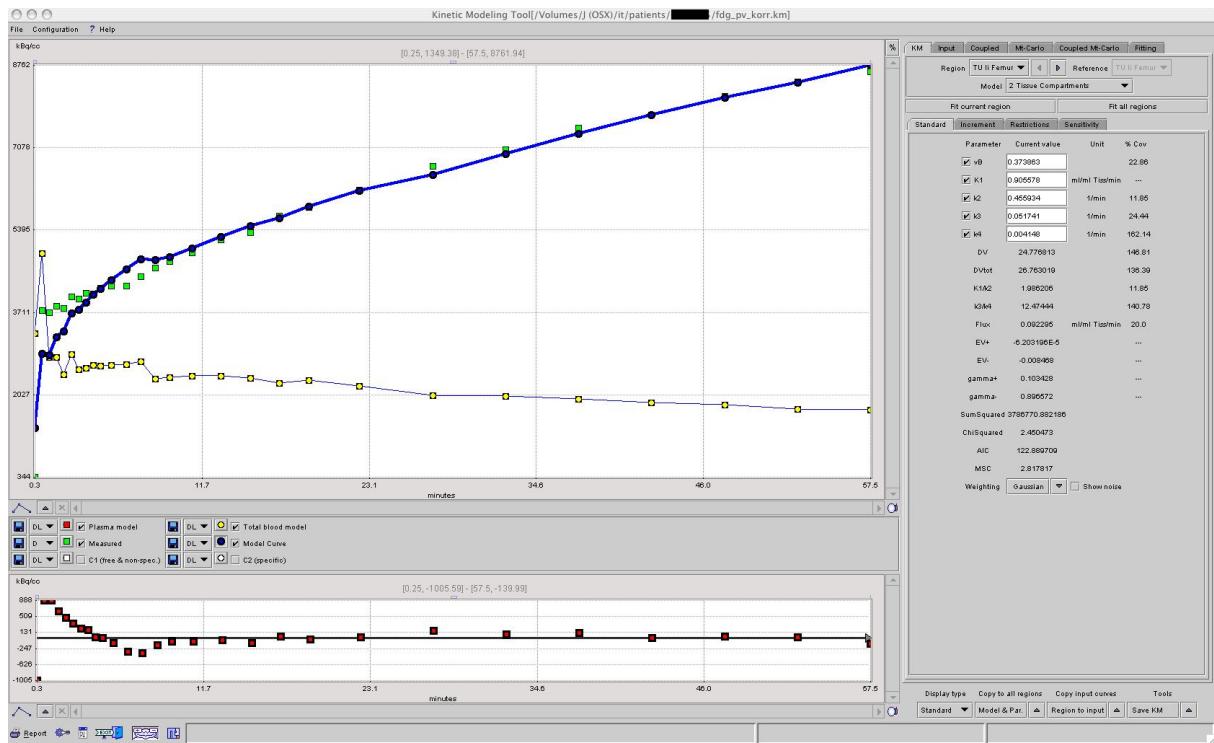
Time-activity data for a giant cell tumor up to 60 min following FDG application. Bold line: time-activity data for the tumor; Thin line: time-activity data for the input function.
